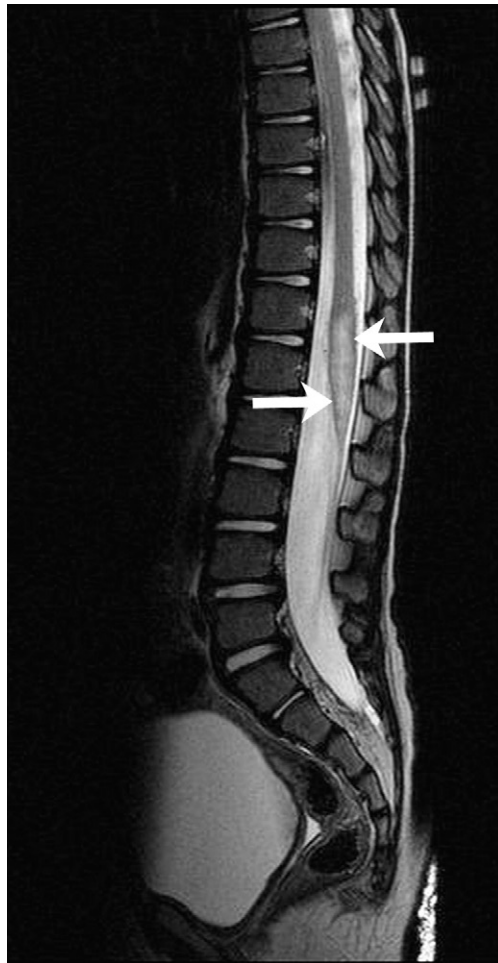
Patient with clinical picture of transverse myelitis. Sagittal T2-weighted MRI of the distal cord shows central T2 hyperintensity within the conus medullaris (arrows) in this case of ADEM. An acute spinal cord infarct also could have this imaging appearance.
